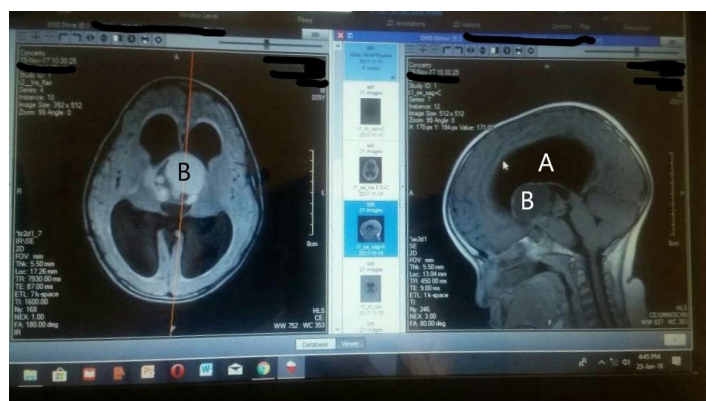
MRI of a 5 year old male showing a huge mass (B) in the region of the Foramina of Monro causing severe obstructive hydrocephalus (A). Picture courtesy of Dr Yusuf AS, Consultant Neurosurgeon, National Hospital Abuja, Nigeria.
